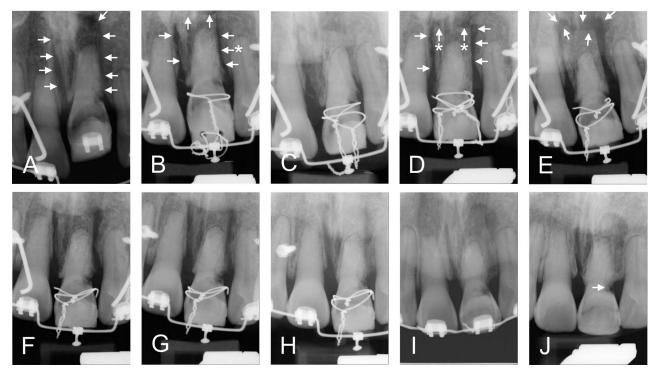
Follow-up radiographs and superimposition at 14 months.
